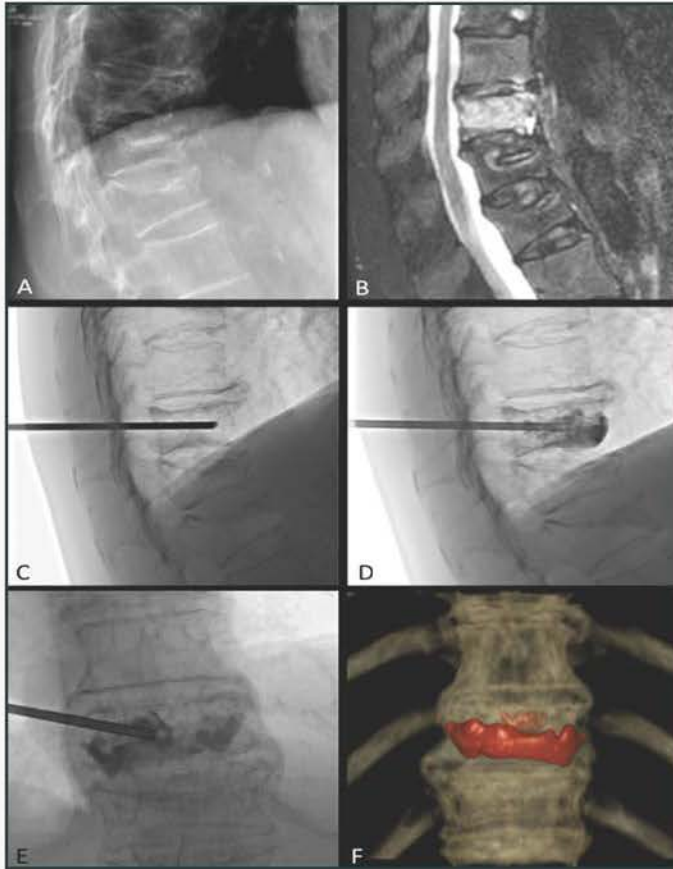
Example of a patient with multiple OVCFs as seen on the plain radiograph (A). On MR Imaging only one vertebra shows intravertebral BME (B). Lateral fluoroscopy images (C) and (D) show insertion of the needle and injection of the bone cement respectively. AP fluoroscopy image of cement injection (E) and 3D CT-reconstruction of the treated vertebra with cement (depicted in red).
